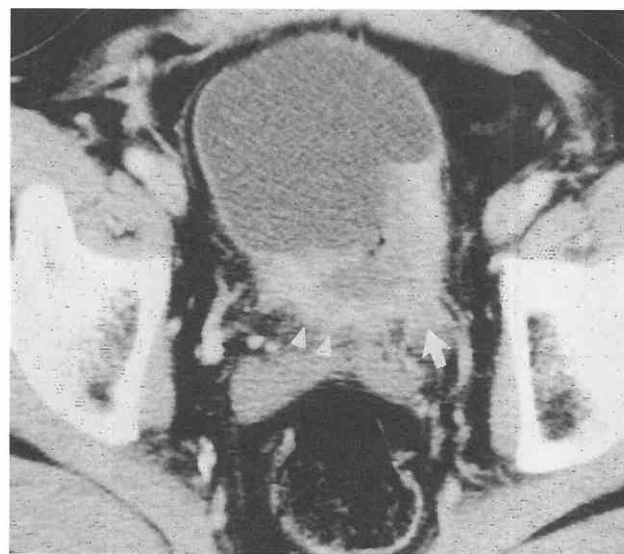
Stage T3b bladder cancer. CT scan through the trigone of the bladder shows an extensive enhancing tumor invading the perivesical fat (arrowheads) and extending up the left ureter (arrow), which is dilated.
